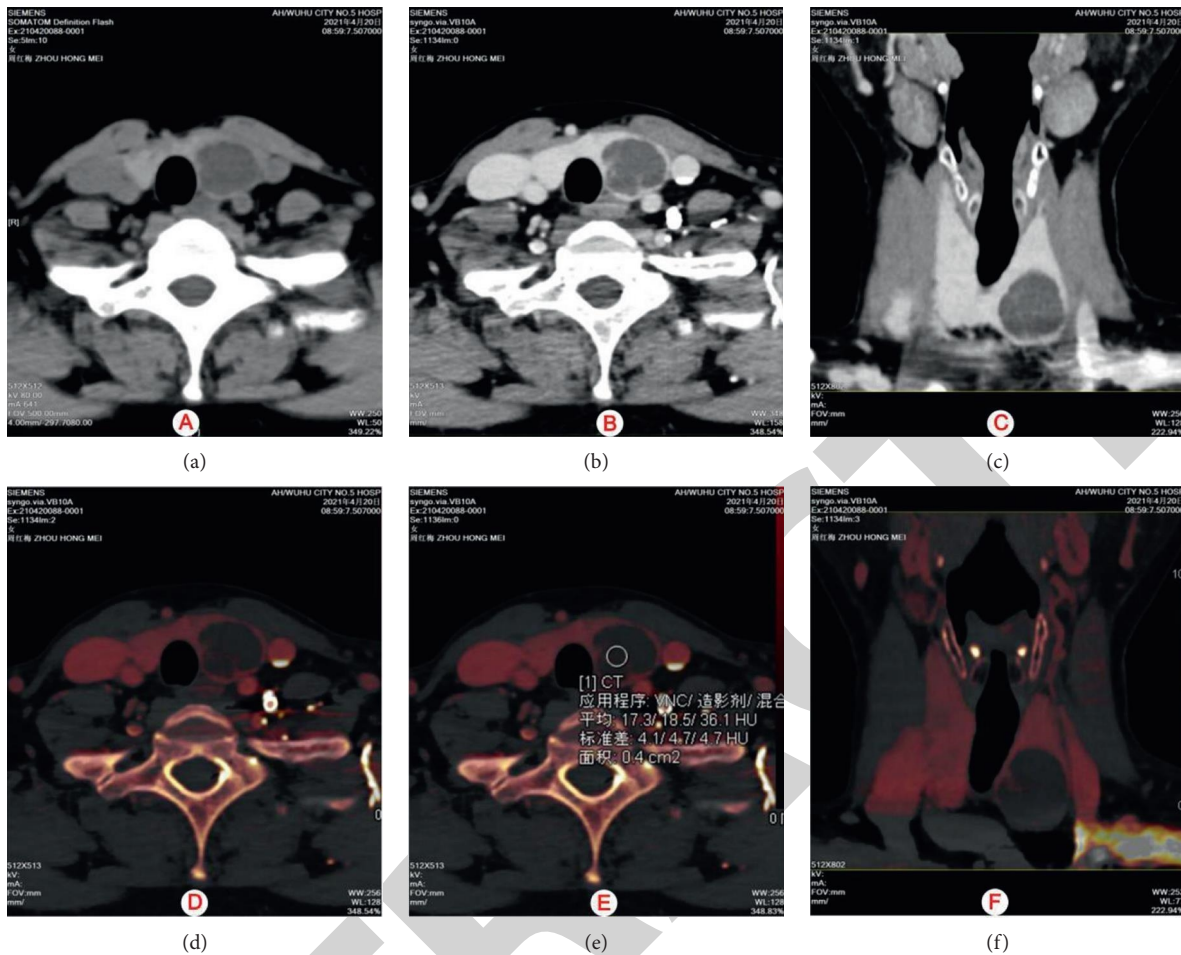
(a)–(f) show the thyroid plain scan image, venous phase image, coronal MPR reconstruction image, iodine coverage image, dual energy image, and coronal iodine coverage image. Patient information: A 52-year-old female was admitted to the hospital with bilateral thyroid masses found on physical examination for 2 years. A multifocal cystic mass was found in the thyroid gland, with a large left lobe and TI-RADS grade 3. CT showed an enlarged left lobe of the thyroid gland with a round cystic low-density shadow of approximately 23×18 mm in size, with a clear border and uniform density, and a visible separation. No significant enhancement was seen in the cystic portion. The iodine image clearly showed the distribution of iodine in the compartment and allowed for quantitative measurement of iodine content, which resulted in the diagnosis of nodular goiter. The postoperative pathology confirmed that the “left thyroid mass” was a nodular goiter with hemorrhage and cystic changes.
